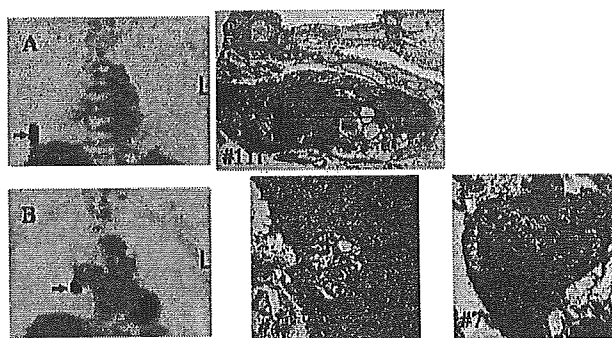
A 67-year-old man with adenocarcinoma in the right lower lobe. CT demonstrated no enlarged lymph nodes. A FDG PET (coronal view) demonstrated increased FDG uptake in the (A) primary tumor (arrow) and (B) a hilar lymph node (arrow) but not in the mediastinal nodes. The maximum dimensions of tumor focus (black line) in the involved LNs were (C) 16 mm in #11i (PET-positive) (D) 1 mm in #4 (PET-negative), and (E) 4.5 mm in #7 lymph node (PET-negative).
